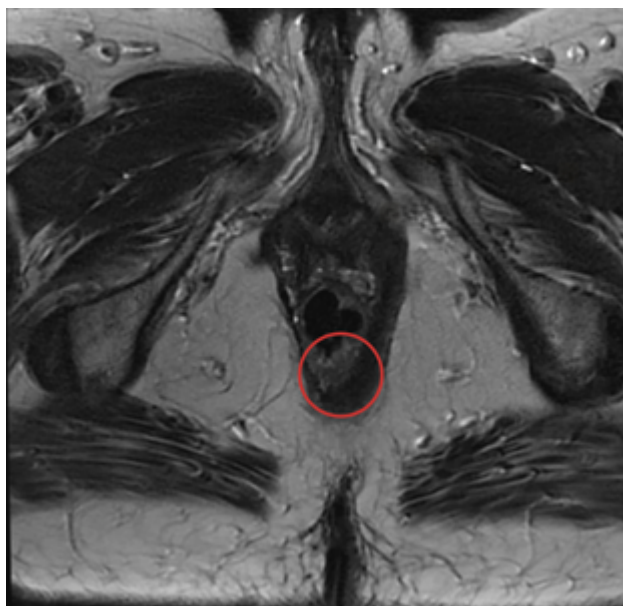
Nuclear magnetic resonance imaging showing mucosal thickening predominantly on the left posterolateral aspect.
